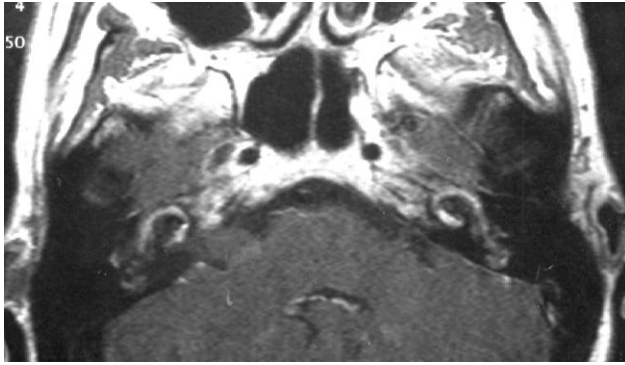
Preoperative MRI (T1 weighed with contrast) of the petrosal bone (transversal view): pericochlear enhancement
